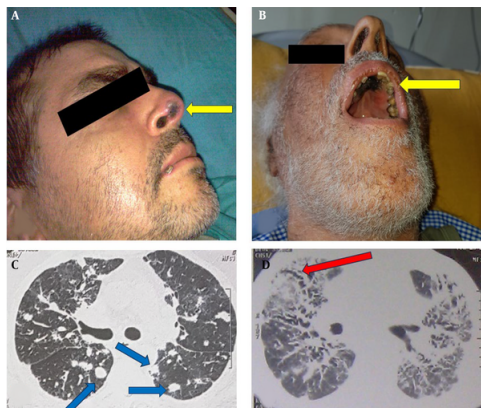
Necrotic skin lesion in the nose (A, yellow arrow) and hard palate (B, yellow arrow). Computed tomography showed pulmonary nodules (C, blue arrow) and air crescent sign (D, red arrow).
